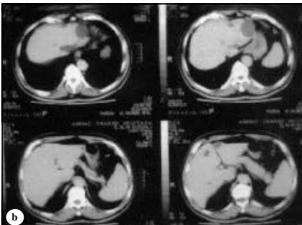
Chest and abdominal CT scan showing a) multiple lung and b) liver metastases
